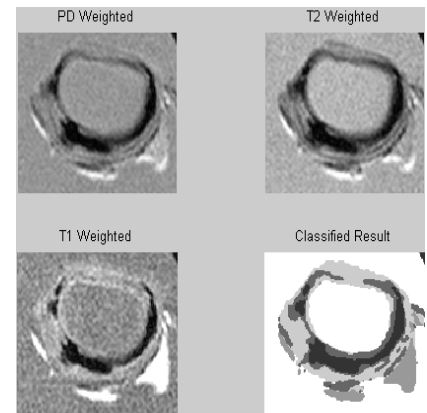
Multi-Contrast MRI of diseased vessel with PFKM result comparison
